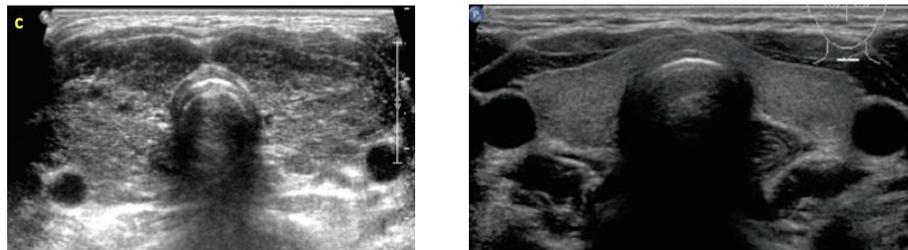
Normal B-mode ultrasound appearance of thyroid with ground glass appearance (a) compared the enlarged heterogamous thyroid of Graves' disease (b)
